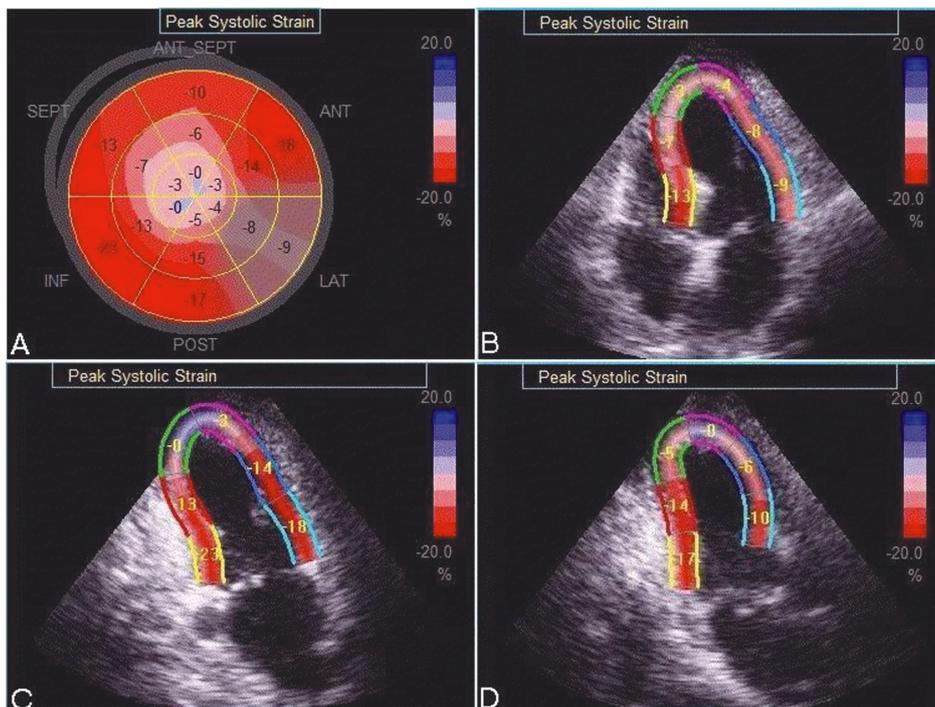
Peak systolic strain of a patient with anterosepto-apical MI. [A] Bull's-eye map, [B] Four-chamber view, [C] Two-chamber view, [D] Apical three-chamber view. Low intensity pink color in the septo-apical-anterior segments is characteristic for septo-apical MI. Gray color in the mid-lateral and lateral basal segments suggests inappropriate tracking of the lateral wall.
